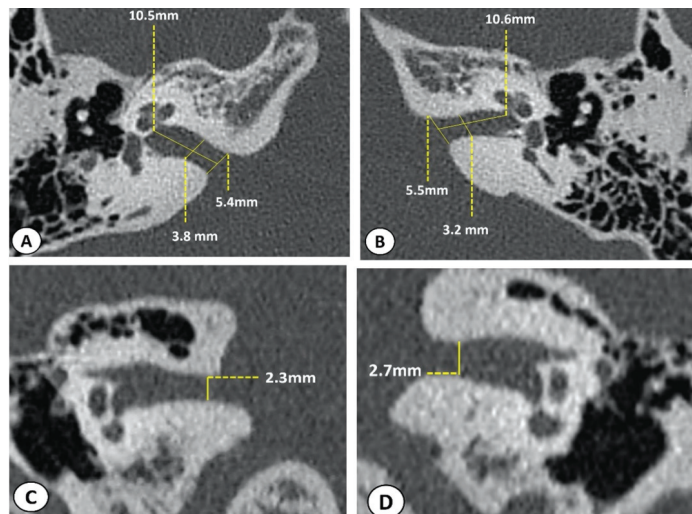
HRCT of temporal bones (IAC sections) confirming a bilateral narrowing of the IAC, in the coronal plane, more pronounced on the right side: (A) right ear, axial plane; (B) left ear, axial plane; (C) right ear, coronal plane; and (D) left ear, coronal plane.
